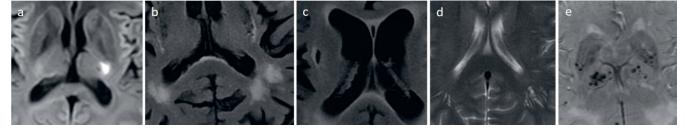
A. Acute lacunar infarction on DWl; B. White matter hyperintensities (WMHs) on the FLAIR image; C. Old lacunar infarction seen on the FLAIR image as a dark fluid-filled cavity surrounded by a hyperintense rim; D. Enlarged perivascular spaces on a T2-weighted image; E. Multiple microbleeds bilaterally within basal ganglia and thalami
